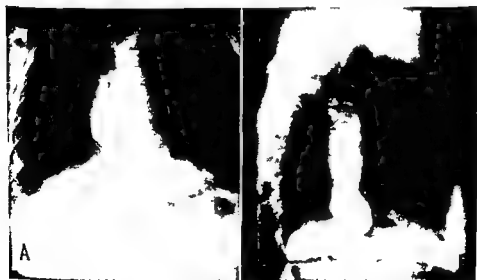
A B Roentgen views postero-anterior and lateral of a patient with Type 1 mega-esophagus (Lee McGregor)
